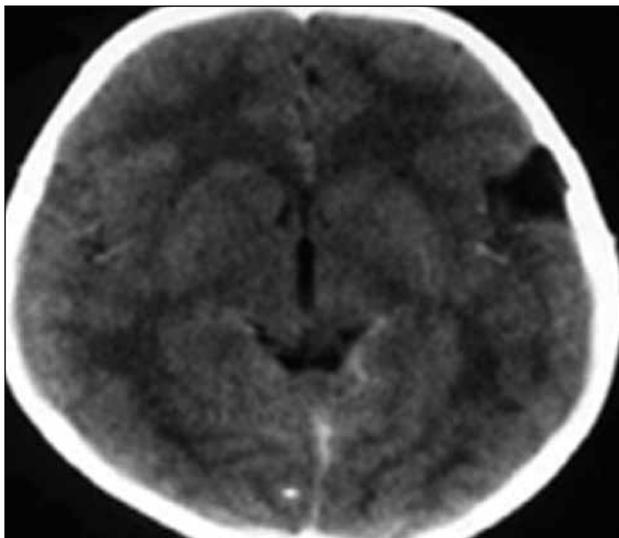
Follow-up CT scan 7½-month later shows calcification of the lesion.
